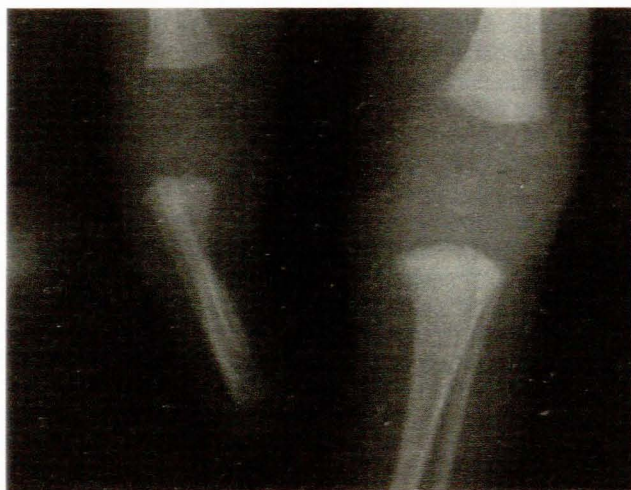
Radiograph of the infant described in this report, showing below-knee limb reduction anomaly of the right leg after a failed attempt at abortion with misoprostol.
